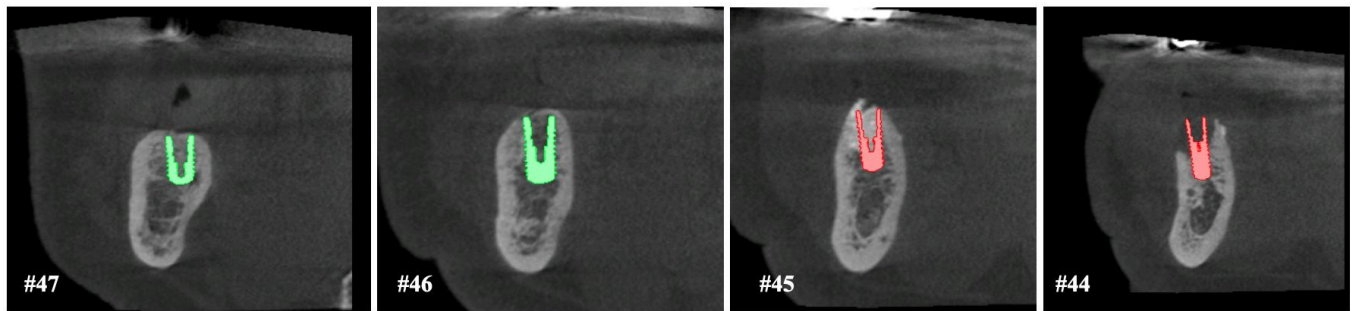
Digital Implantology Planning with CBCT in the fourth quadrant (#44,45,46,47).
